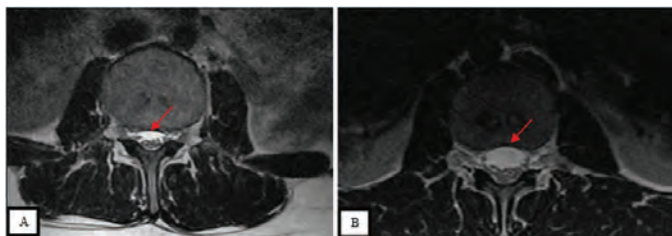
A) Axial lumbar T2w MR image of a 32-year-old female with short pedicles shows a compressed appearance of the lumbar spinal canal (A, arrow) B) axial lumbar T2w MR image of a 22-year-old female with normal pedicle lengths shows a more rounded (non-compressed) appearance of the lumbar spinal canal (B, arrow)
